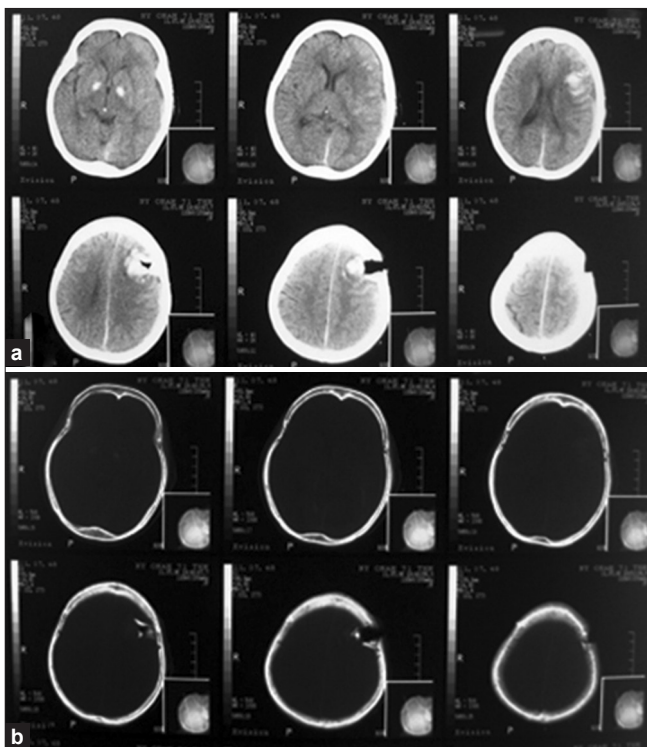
(a) Brain CT scan revealing a large depressed fracture over left frontal region; (b) Brain CT scan with bone window to confirmed a large depressed fracture over left frontal region
